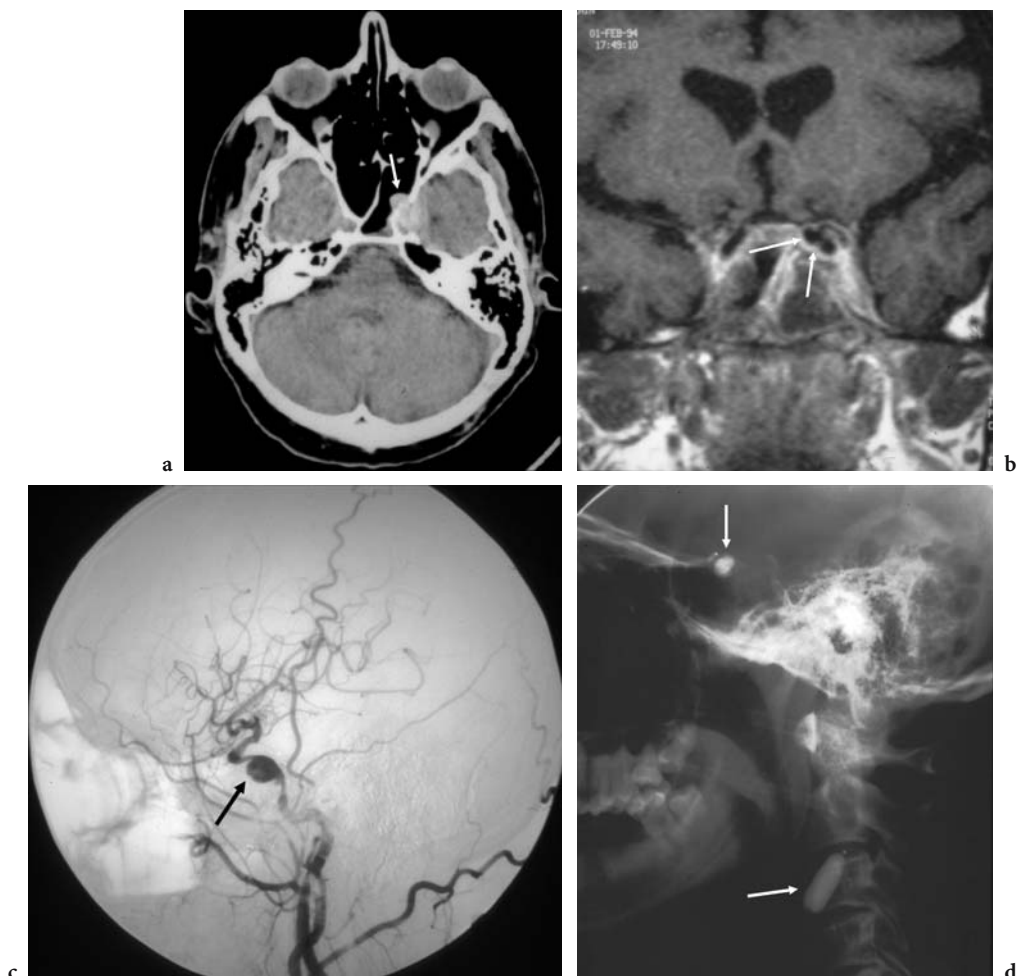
A patient with sphenoid sinusitis treated by antibiotics therapy who developed sudden EPX. CT a and MR b showed enlargement of the left cavernous sinus with a structure bulging into the sphenoid sinus (a: arrow) and an irregular aspect of the internal carotid artery (b: arrows). An infectious false aneurysm was suspected and the patient underwent emergent angiography. A left common carotid artery injection (c, lateral view) confirmed the lesion (c: arrow) on the cavernous portion of the internal carotid artery, which was also stenosed. Sacrifice of the internal carotid artery (with trapping of the pathological zone) was performed with occlusion balloons (arrows) after a satisfactory tolerance test d
